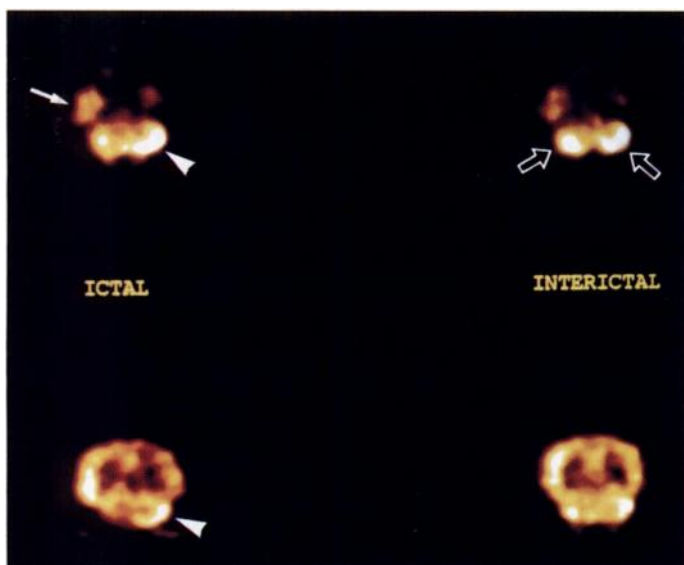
Right temporal lobe epilepsy in a 16-yr-old boy. Ictal SPECT shows increased uptake in right temporal lobe (arrow) and left cerebellar hemisphere (arrowhead). Interictal SPECT shows normal activity within the cerebellum (open arrows).
